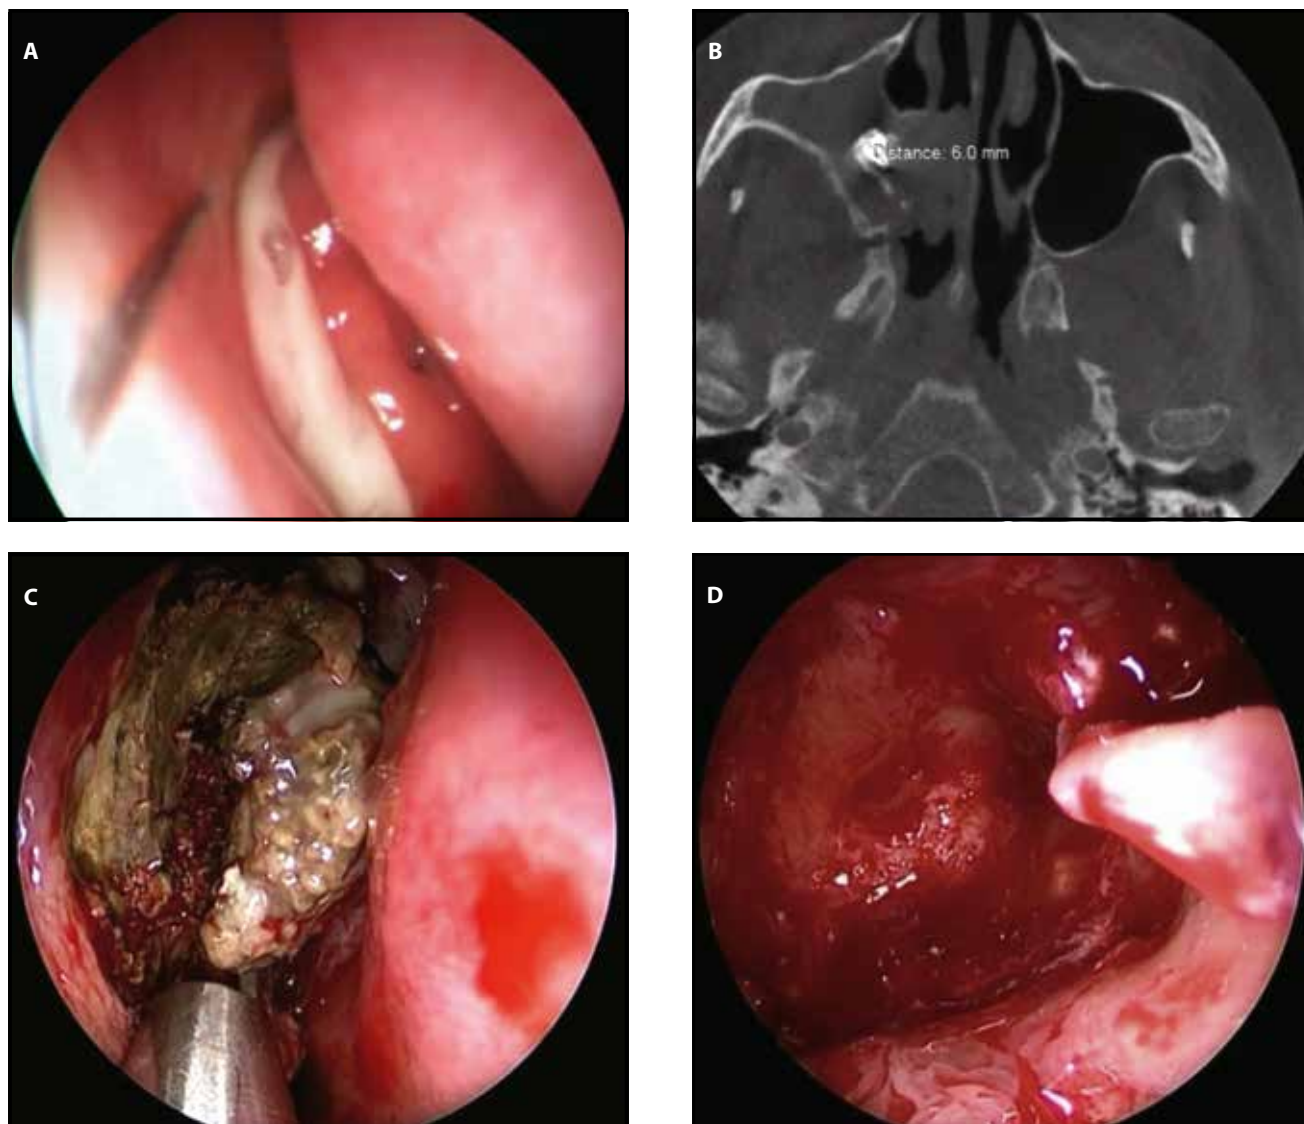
A Nasal endoscopy showing edema and purulent secretions in the right middle meatus. B Axial cranio-facial CT scan - radiopaque foreign body in the right maxillary sinus (filling material) covered by fungal material, located close to the ostium of the maxillary sinus. C Intraoperative view: after saline irrigation, a small brownish mass is observed in the area of the maxillary sinus. D Intraoperative view of the maxillary sinus at the end of the surgery.
